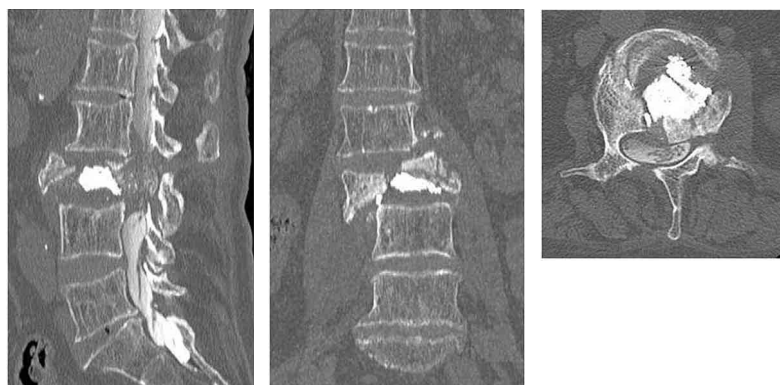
Reconstructed CT scans revealing the fractures of the vertebral body, bilateral pedicles, and lamina.
